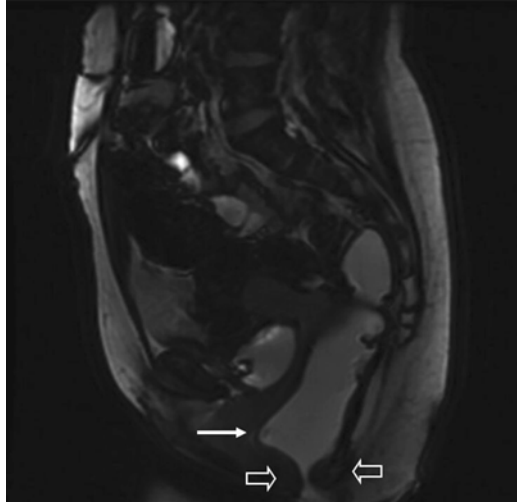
Dynamic pelvic MRI: normal evacuation. Dynamic pelvic MRI demonstrating evacuation (a–c)
